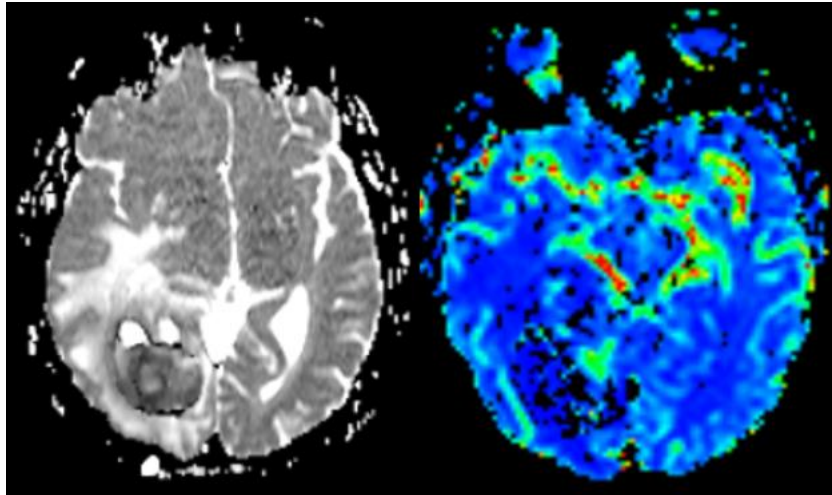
MRI DWI and perfusion in GBM
